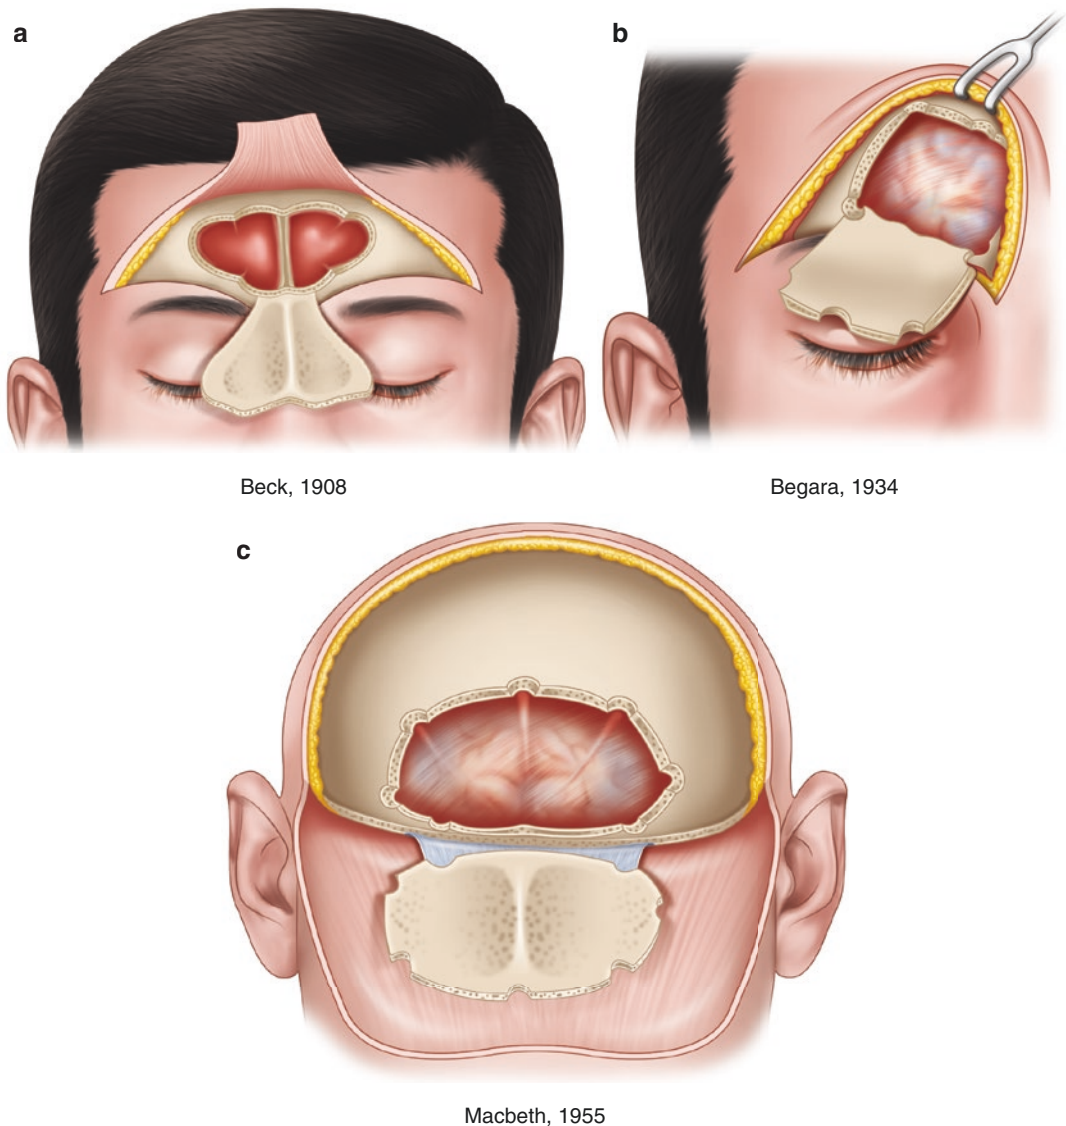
Osteoplastic flap techniques as described in J. Dawes in *The Management of Frontal Sinusitis and its Complications*, *J. Laryngology and Otology*, 1961 [13]. Beck described in 1908 the use of radiographic guidance in his
